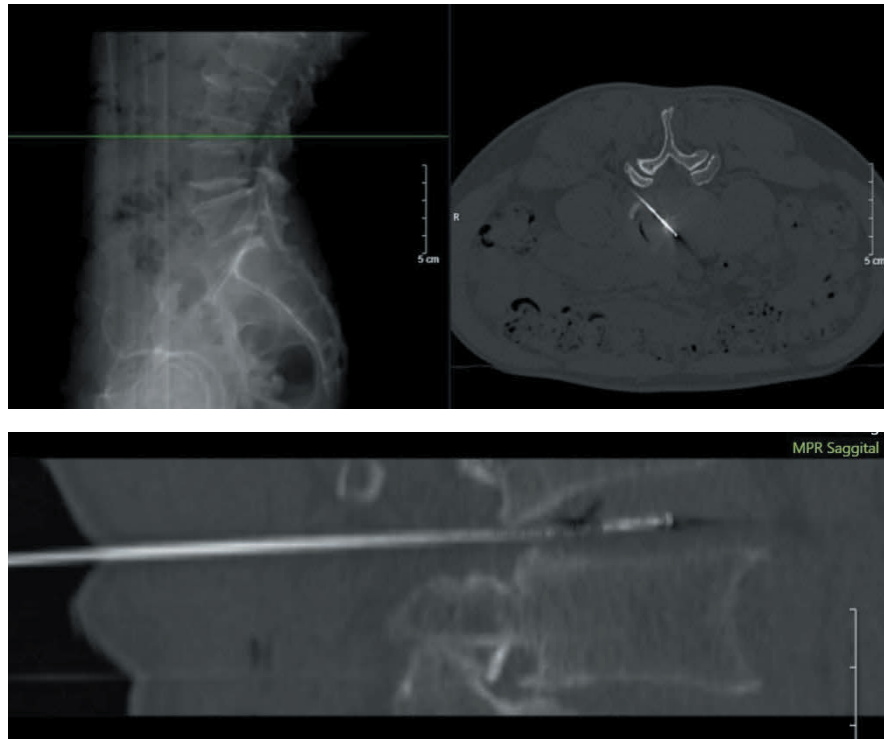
Percutaneous plasma decompression of the L3/4 disc under CT guidance on February 17, 2025.
